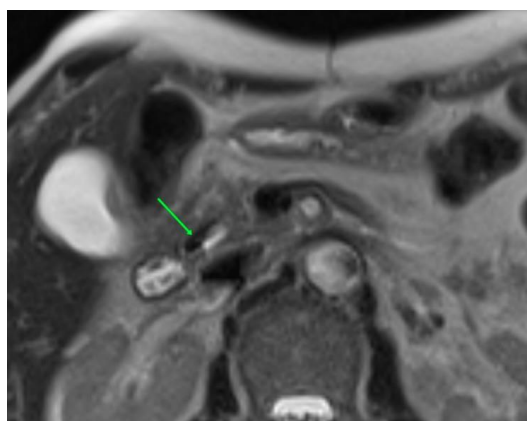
Axial T2-weighted MRI — Case 2: A 17×8 mm air-containing periapillary duodenal diverticulum (green arrow) on the medial wall of D2, in close proximity to the ampulla of Vater. No biliary or pancreatic ductal dilation in the intercritical period
